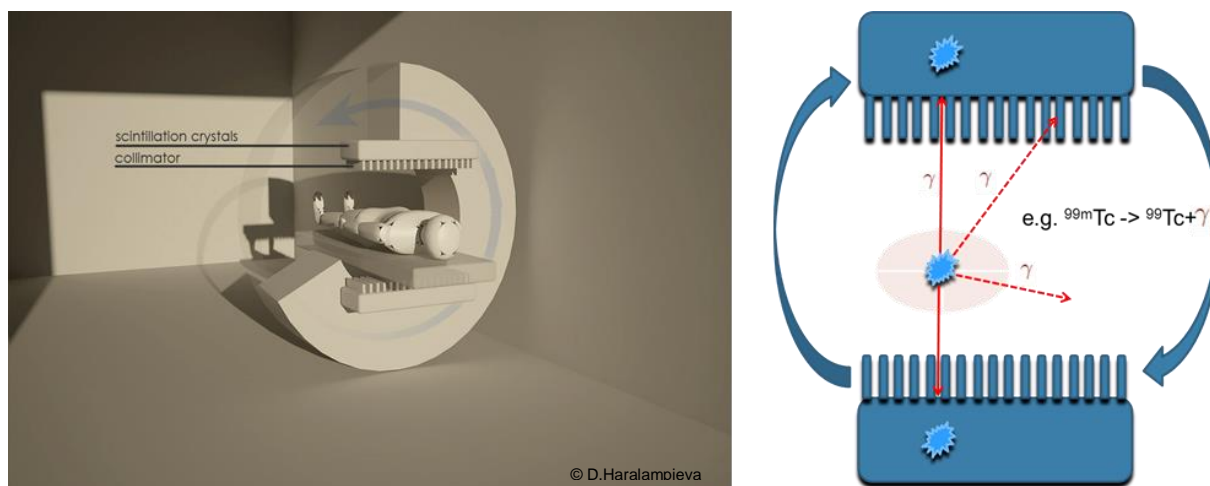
Underlying principle of SPECT: (1) A radioisotope decays by emitting gamma rays. (2) A rotating gamma-sensitive detector with a collimator in front indicates the scintillation site where gamma rays are parallel to the collimator pinholes. (3) The collected data is then transferred to photo-multipliers and finally to a computer for analysis.
